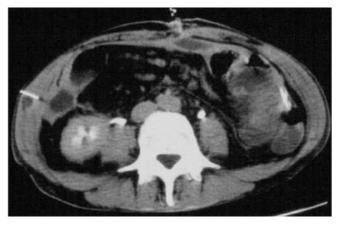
Axial CT image of a thick-walled fluid collection <3 cm in diameter, considered an indication for simple diagnostic aspiration. A Chiba needle is shown approaching the abscess to collect a fluid sample for diagnostic cultures
